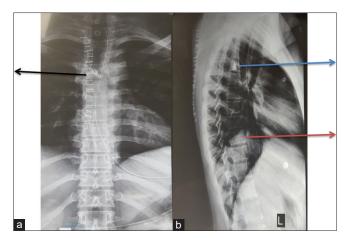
Post-operative anteroposterior and lateral radiograph of the spine. (a) Anteroposterior radiograph demonstrates the radioopaque cement injected into the T4 vertebral body (black arrow). (b) Cement can be seen in T4 on lateral view. A striated pattern can be demonstrated in the T9 vertebral body (red arrow), suggestive of a vertebral body hemangioma
